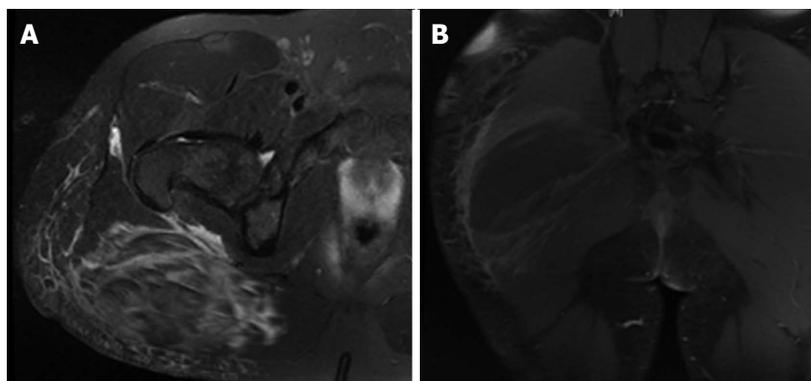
Magnetic resonance image. A: Axial PD FS MR image showing increased T2 signal in the gluteus maximus, with fluid extension to the trochanteric bursa and semitendinosus bursa, fluid in the deep fascia, and subcutaneous edema. There was no hip joint effusion; B: Coronal contrast-enhanced RT FS MR image showing a central 13 cm × 5 cm area of non-enhancement in the gluteus maximus, suggestive of a hematoma. MR: Magnetic resonance.
